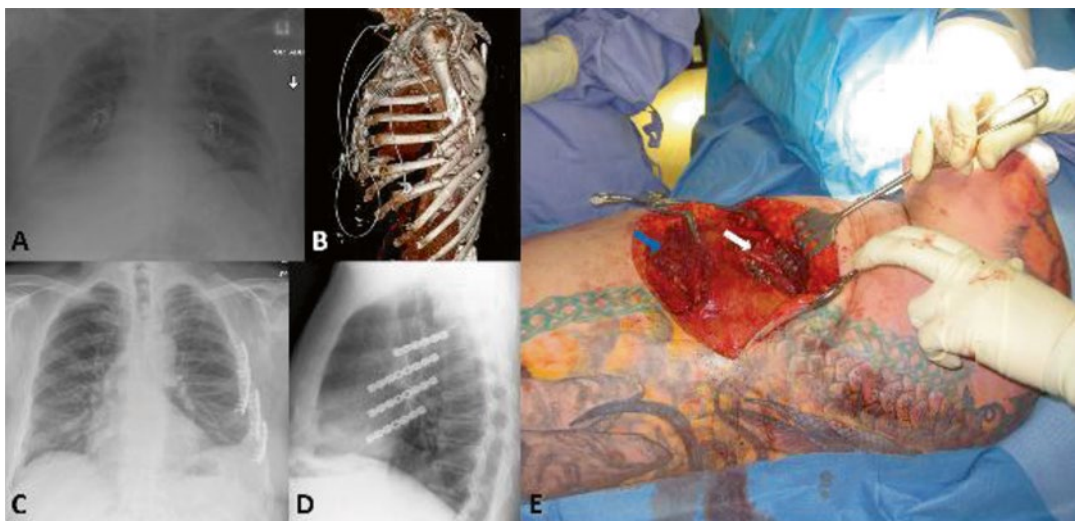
(a) AP chest radiograph in a 48-year-old male demonstrating a left-sided flail chest and multiple displaced/comminuted anterolateral rib fractures. (b) 3D CT reconstruction in the same patient demonstrating multiple left-sided, anterolateral rib fractures with substantial displacement/comminution. (c and d) Postoperative PA and lateral chest radiograph in the same patient demonstrating
